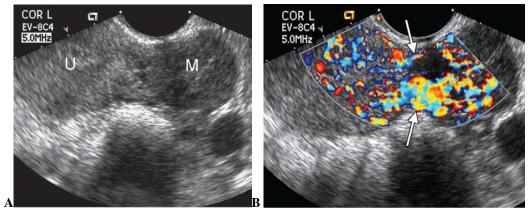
Pedunculated. (A) Coronal transvaginal US scandemonstrates a solid adnexal mass (M) adjacent to the left side of theuterus (U). (B) Colour Doppler US scan in the same plane shows connecting vessels (arrows) between the uterus and mass, helping to confirm a pedunculated leiomyoma.
